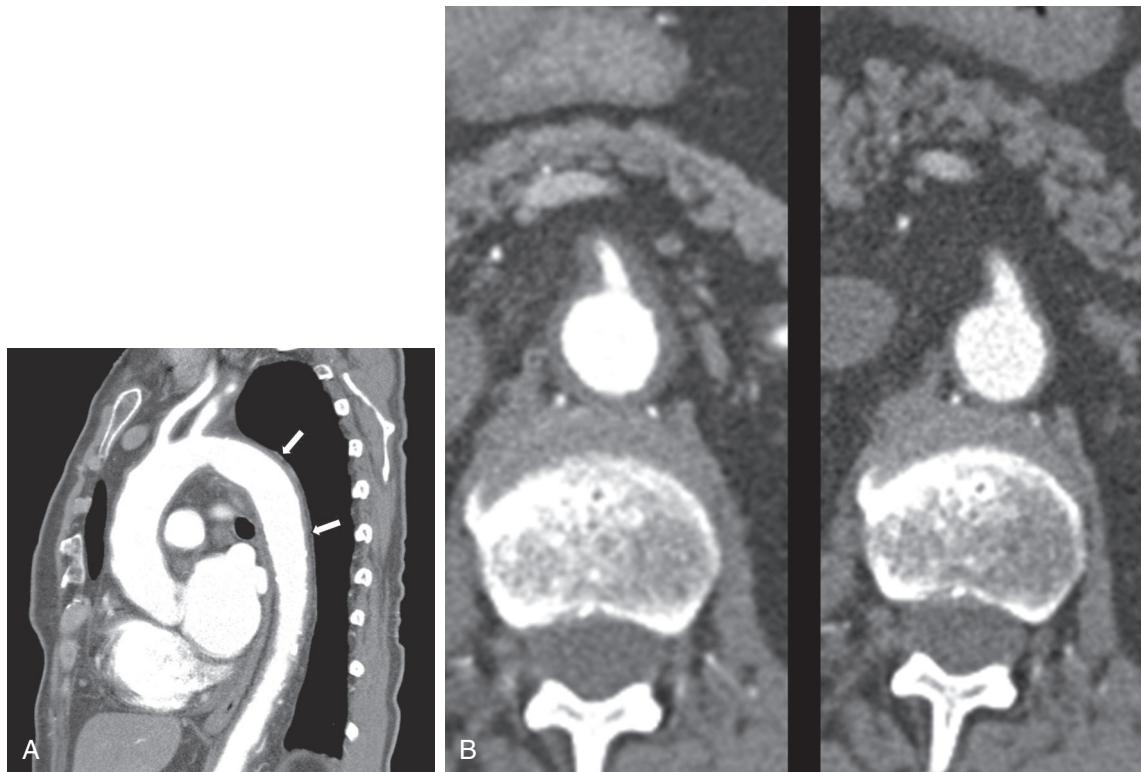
Computed Tomography Angiogram of a Patient with Giant Cell Arteritis and Involvement of the Aorta. (A) This sagittal image demonstrates thickened arterial walls, most prominent in the great vessels, and throughout the entire descending thoracic aorta. (B) Arterial wall thickening extended into the upper abdominal aorta and superior mesenteric artery (SMA), which was stenosed (*left panel*). Reimaging after 6 months of treatment with corticosteroids revealed marked improvement in the diffuse arterial wall thickening and SMA stenosis (*right panel*).
